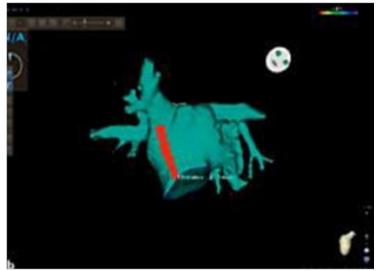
Distance between right superior pulmonary veins and mitral annulus as measured in computed tomography. (adapted from reference [10]).
